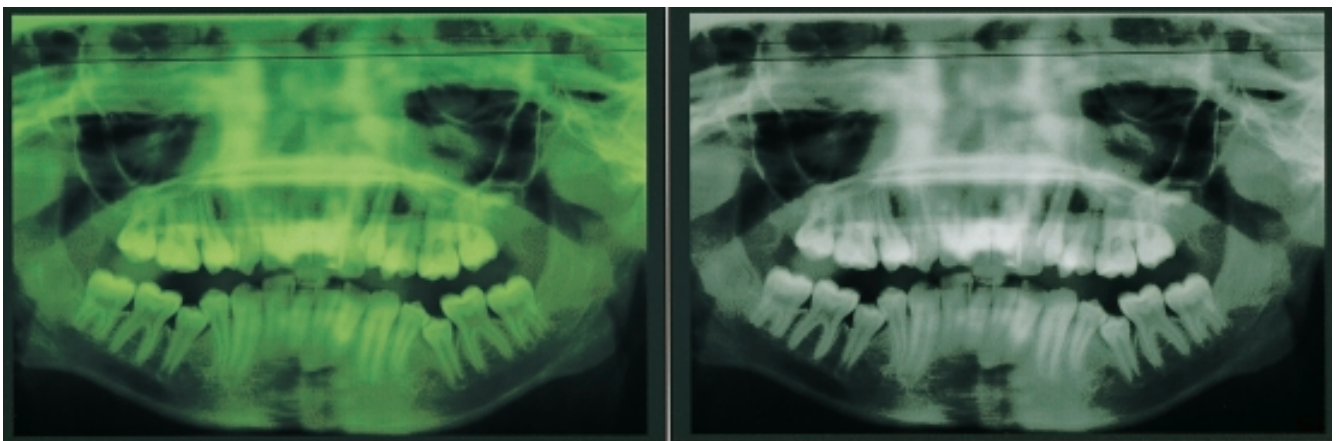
Radiographs captured digitally and converted to grayscale.
